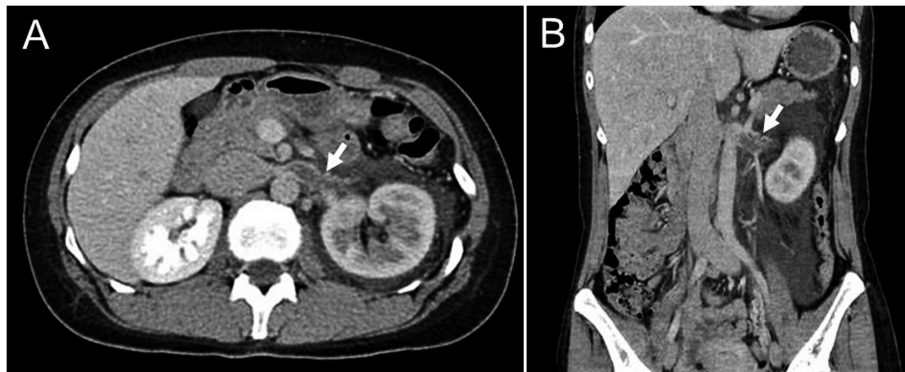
Radiological examination at the onset. (A) Axial image of abdominal computed tomography (CT) scan with contrast showed a large thrombus in the left renal vein (arrow) and an enlarged left kidney with perirenal stranding. (B) Coronal image of abdominal CT scan with contrast showed a large thrombus in the left renal vein (arrow).
